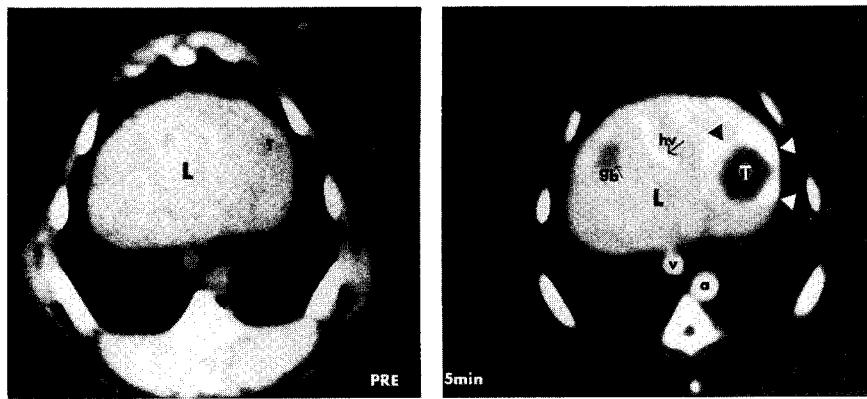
FIGURE I CT image of the liver with implanted VX2 tumors taken pre and 5 min post Imagent® BP administration. Note that while the tumor center (T) was nearly isodense with liver (L) pre-contrast, it became markedly hypodense at 5 min because of the biodistribution of Imagent® BP (the tumor is hypovascular compared to the liver).
